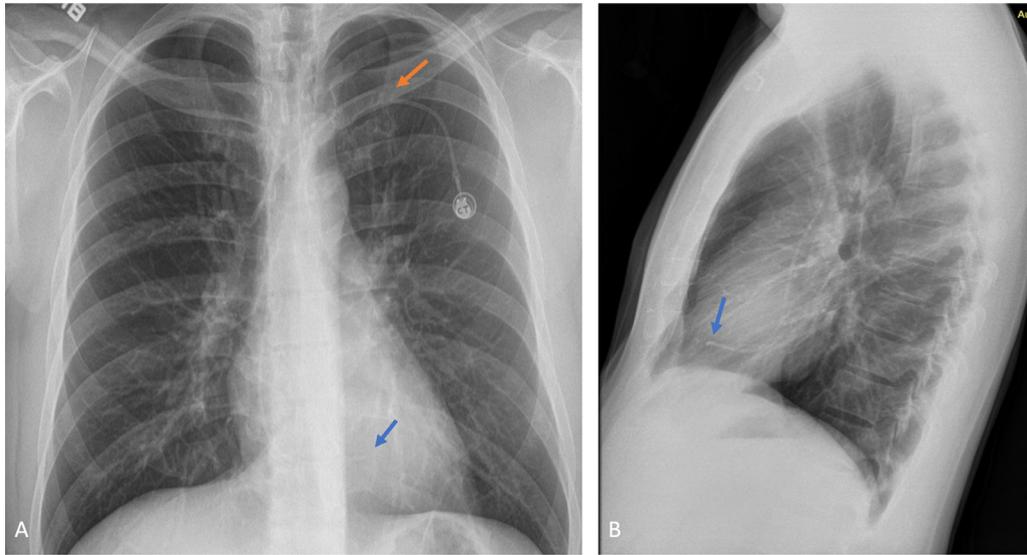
Chest X-ray in PA (A) and lateral (B) projections showing an image suggestive of rupture of the chemotherapy catheter at the level of the left clavicle and the outer border of the first left rib (orange arrow). The distal segment of the catheter is lodged in the right ventricle (blue arrows).
